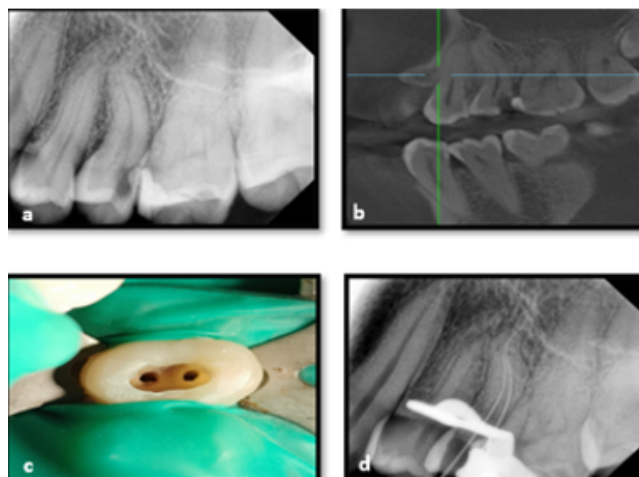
a:) Preoperative radiograph showing doubly curved (Bayonet or 'S' shaped) root canal in relation to 25, b:) CBCT image showing curved canals of 25, c:) Intraoral photograph of access opening, d:) Working length radiograph.
